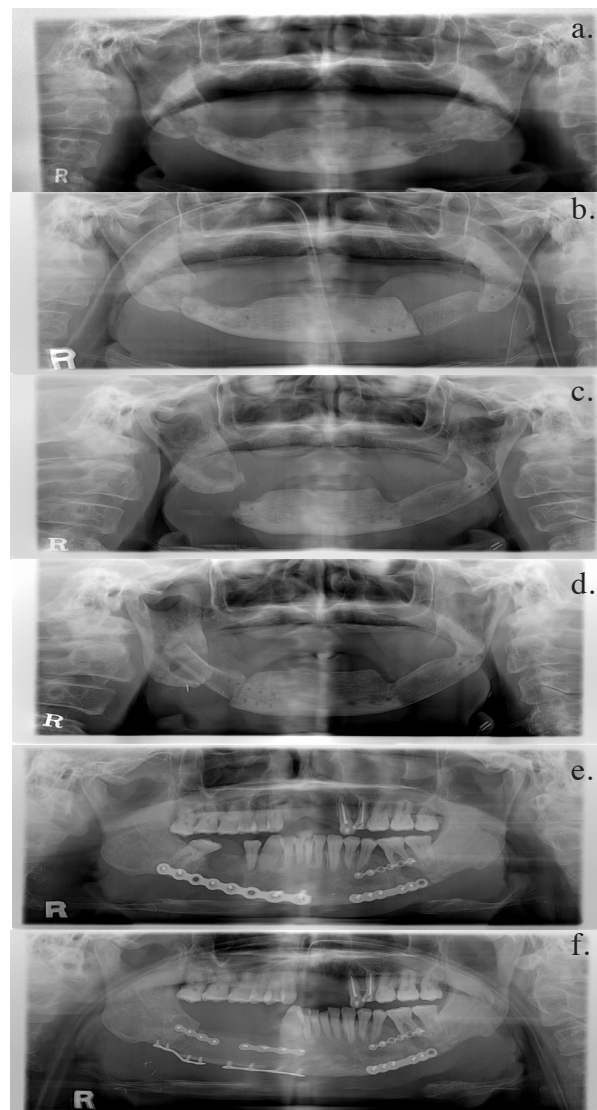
Panoramic X-ray before and after Surgery Case 1. Osteoradionecrosis with Pathologic Fracture on both Mandibular Body and Panoramic X-ray before and after Surgery Case 4. Osteomyelitis on Right Mandibular Body due to Nonunion. a. Before surgery, b. After reconstruction of mandibular left side, c. After management of inflammation on the mandibular right side, d. After reconstruction of mandibular right side, e. Before surgery, f. After segmental mandibulectomy on the right side, and the reconstructive surgery was done.
